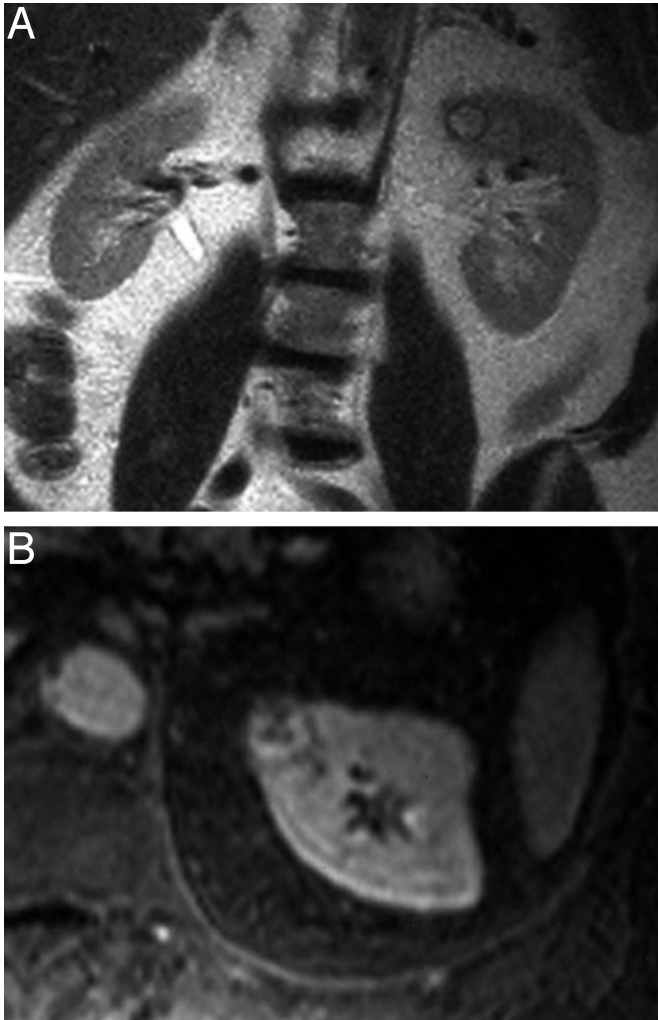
Coronal T1 MRI of left renal lesion (A); transverse T2 MRI of same lesion (B).
